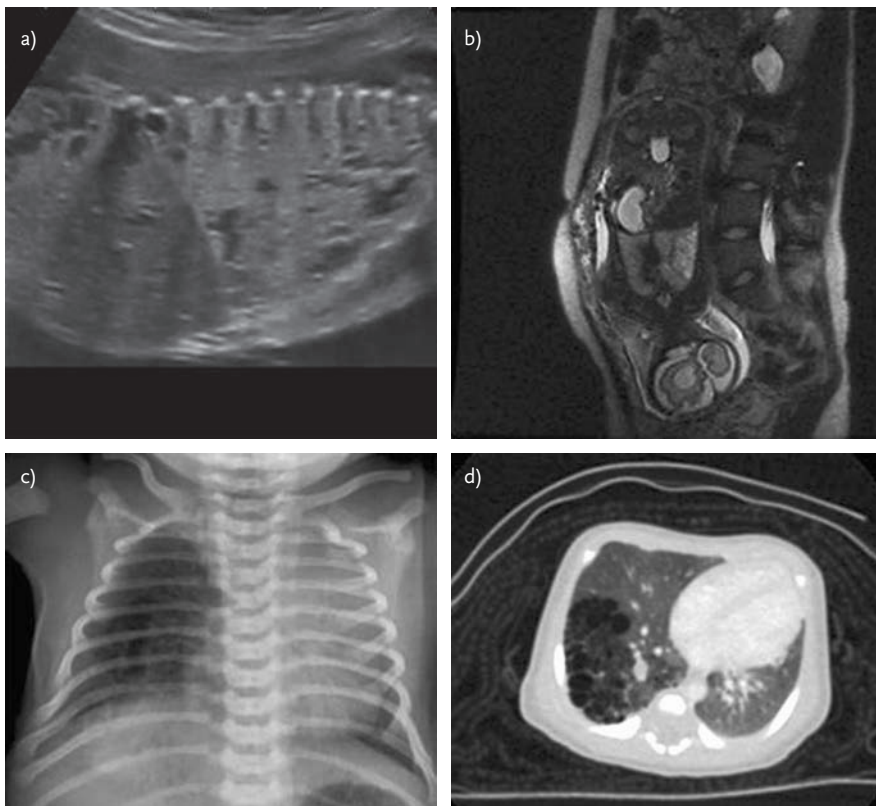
a) Antenatal ultrasound and b) MRI scan of an extensive right sided CCAM, which was symptomatic at birth, with respiratory distress and mediastinal shift as confirmed by c) a chest radiograph and d) a CT scan. It was surgically removed successfully at 3 days of age.
